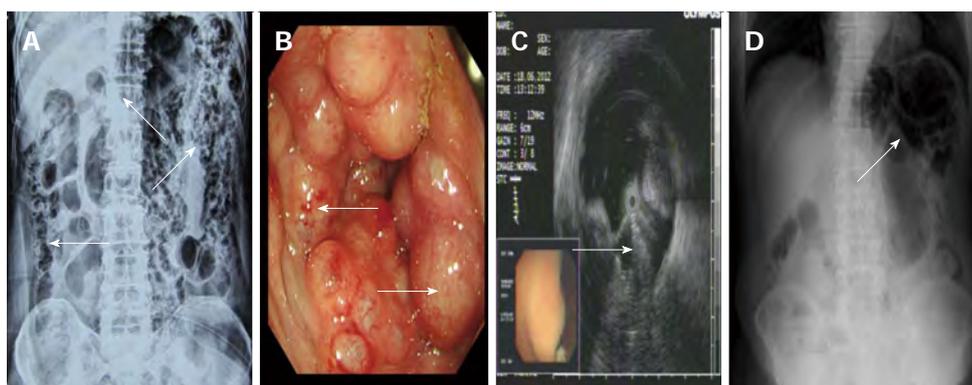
Imaging features of pneumatosis cystoides intestinalis. A: Barium enema study revealing multiple polypoid lesions with air shadows (arrow) and grape-like intramural gas in the whole colon; B: Colonoscopy revealing multiple round and smooth-surfaced elevated lesions (arrow) similar to submucosal tumors in the colon; C: Endoscopic ultrasonography revealing hyperechoic lesions and acoustic shadows in the submucosal layer (arrow); D: Plain radiography of the left upper quadrant abdomen revealing dilatation of the intestine and small linear, round radiolucent areas (arrow) on the clusters in the wall of the colon.
